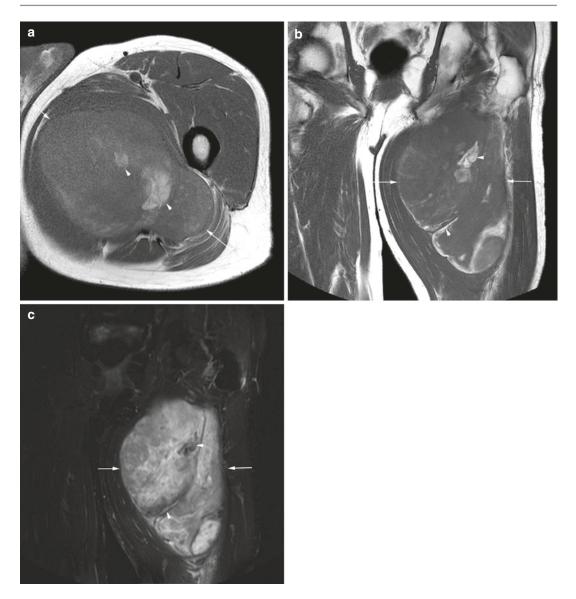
(a–c) Dedifferentiated liposarcoma of the left thigh. (a) Axial. (b) Coronal SE T1-weighted MR images. (c) Coronal fat-suppressed SE T2-weighted MR image.
